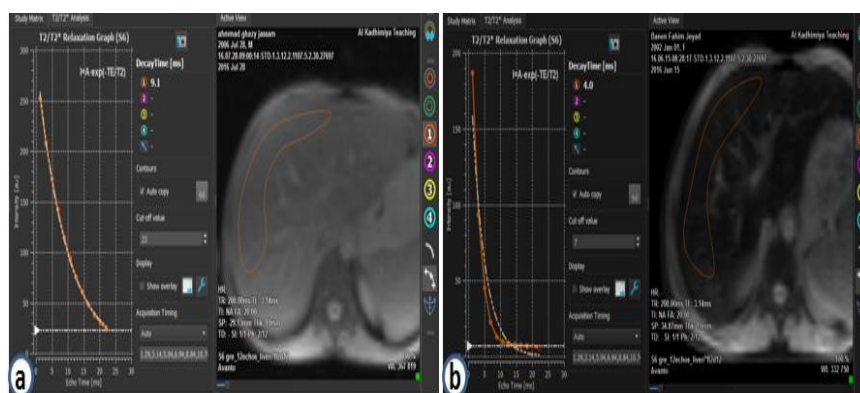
a: 10 years old male patient with beta-thalassemia major, MRI shows mild liver iron deposition, LIC =3.4 mg/gm. b: another 14 years old female patient with beta-thalassemia major, MRI shows a moderate liver iron deposition, LIC=7.83mg/gm.
